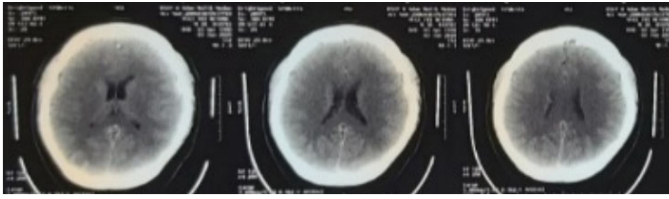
Cranial CT scan (normal).
